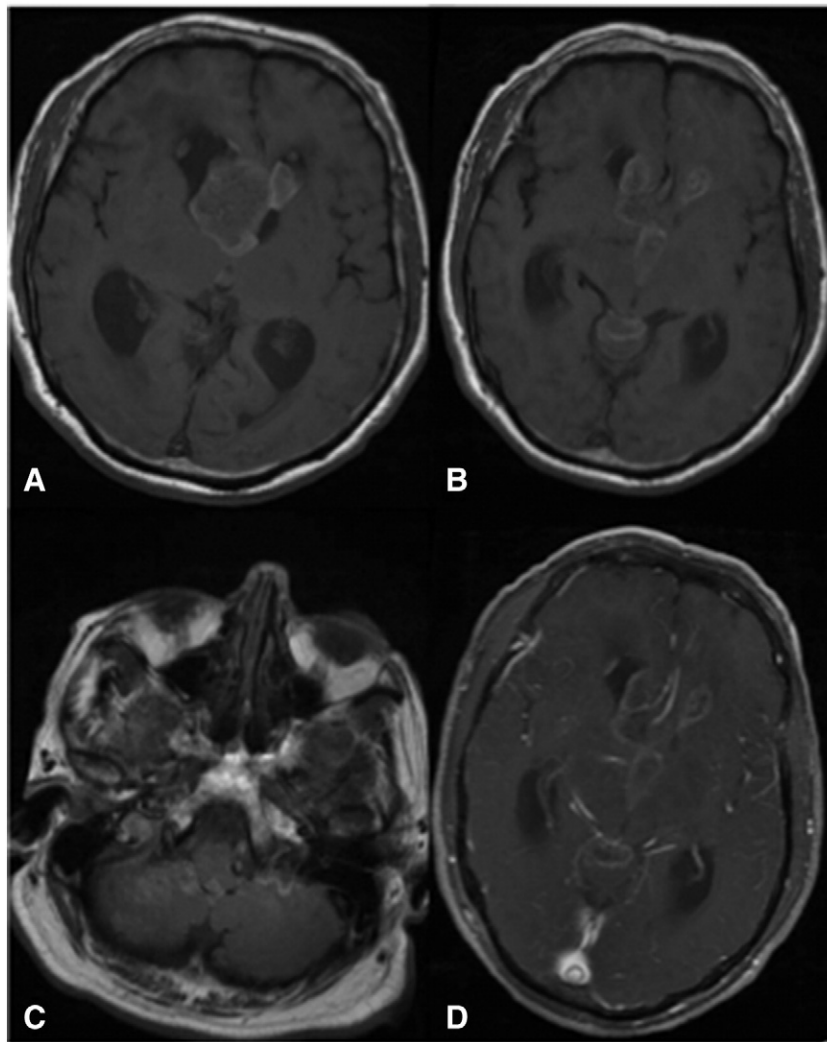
MRI preoperative examination. (A–C) Axial T1-weighted images reveal multiple intraventricular masses involving the lateral, third, and fourth ventricles. Multiple leptomeningeal lesions are also noted in the fissures of the cerebellum and along the flocculi. All the masses appear hyperintense on T1-weighted images. (D) Axial postcontrast T1-weighted image demonstrates only mild peripheral enhancement.
